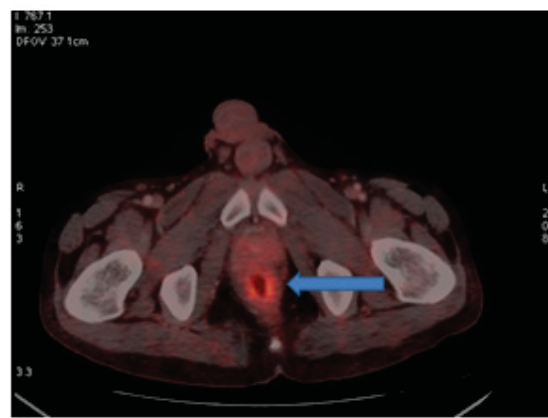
PET/CT scan of above patient after neoadjuvant CRT, tumor uptake (SUV_{max} 4.6). The TRG was 1
